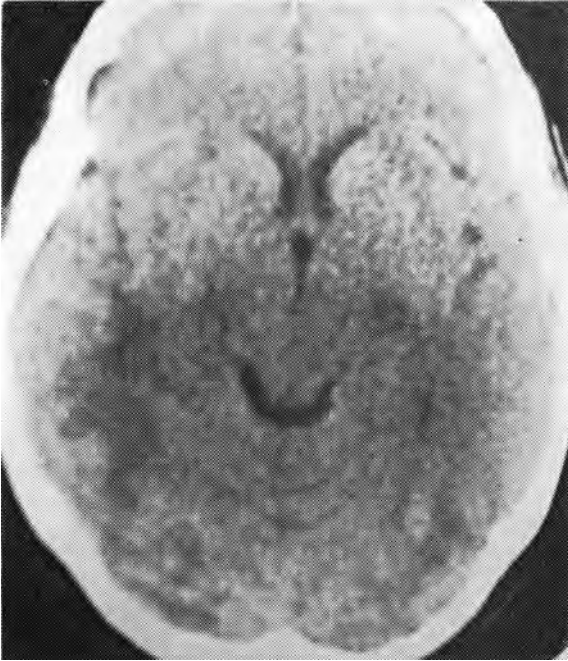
CT scan demonstrates remission of the previous lesions.
